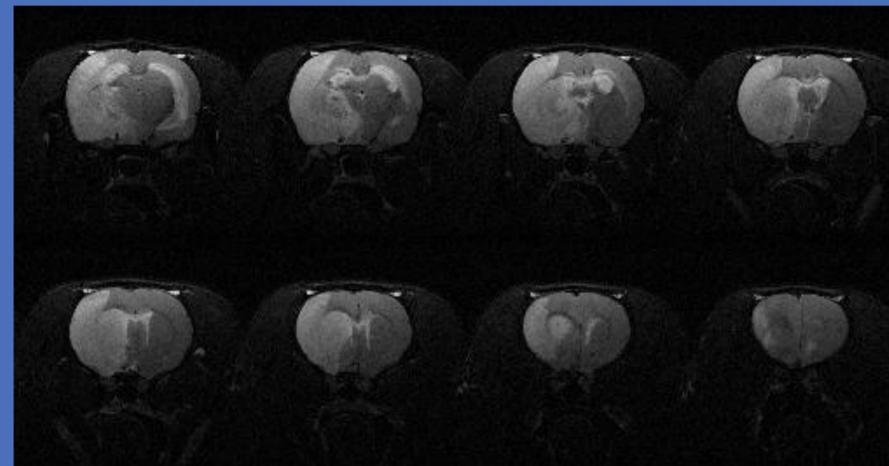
T2 MRI 24 hours after MCAO
